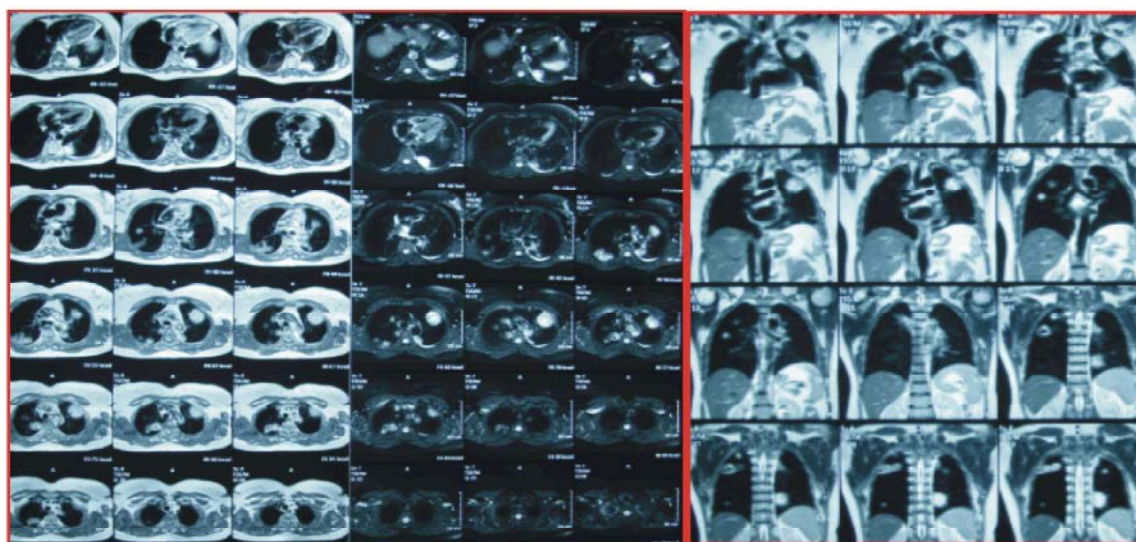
Pulmonary MRI revealed multiple speculated intrapulmonary mass(41x44mm) and(15x9mm) in left upper lobe, (36x30mm)in left lower lobe and (22x15mm),(16x16mm),(46x16mm),(27x26mm), (29x12mm)in right middle lobe and upper lobes of lungs.
